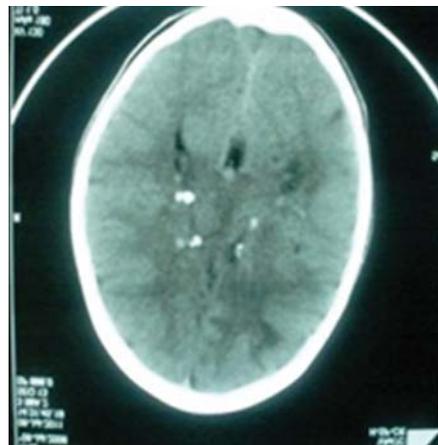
The CT Scan head showing subependymal nodules
